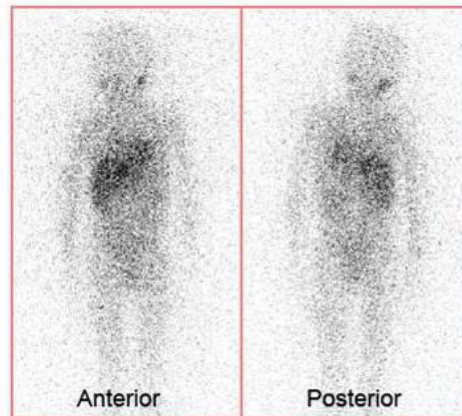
A 6 years old male child presented with hypertension. CT demonstrated Rt. Adr mass. MIBG scan revealed tran activity - s/o pheochromocytoma
